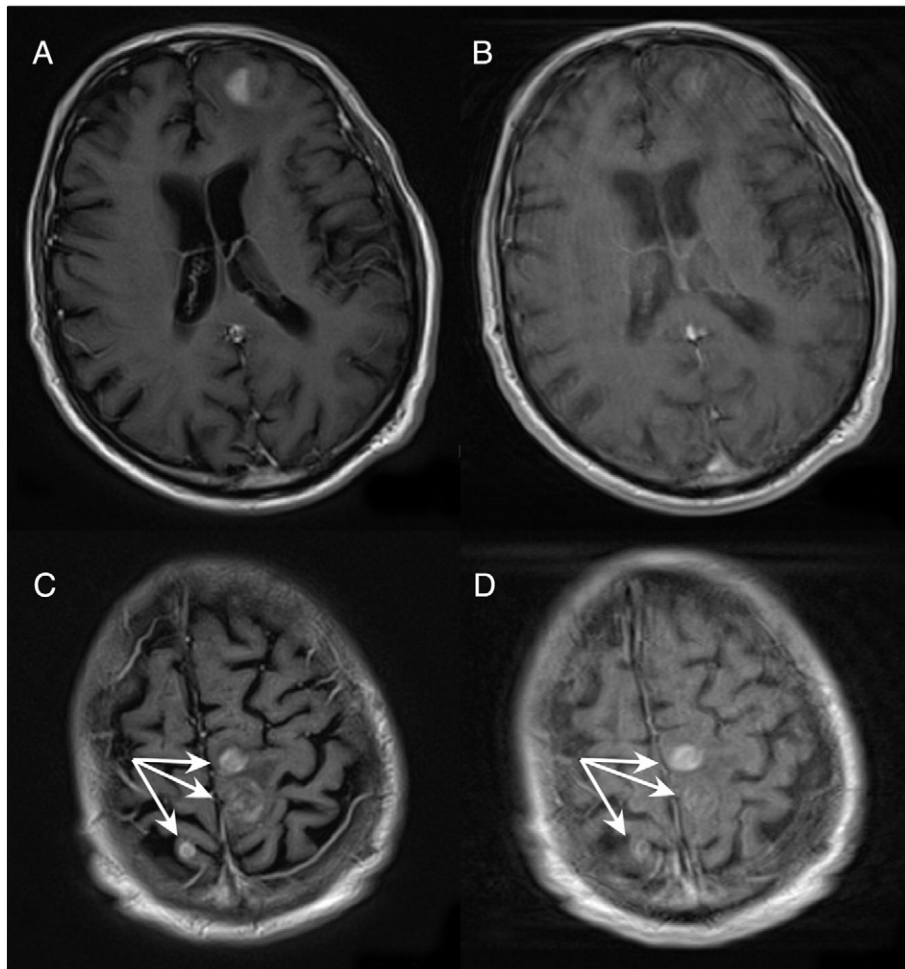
Sequences: T1W FLAIR BLADE with contrast medium (A, C), T1W SE with contrast medium (B, D). The arrow shows the cerebellar metastasis which is better enhanced in the BLADE sequence than in the conventional SE.
